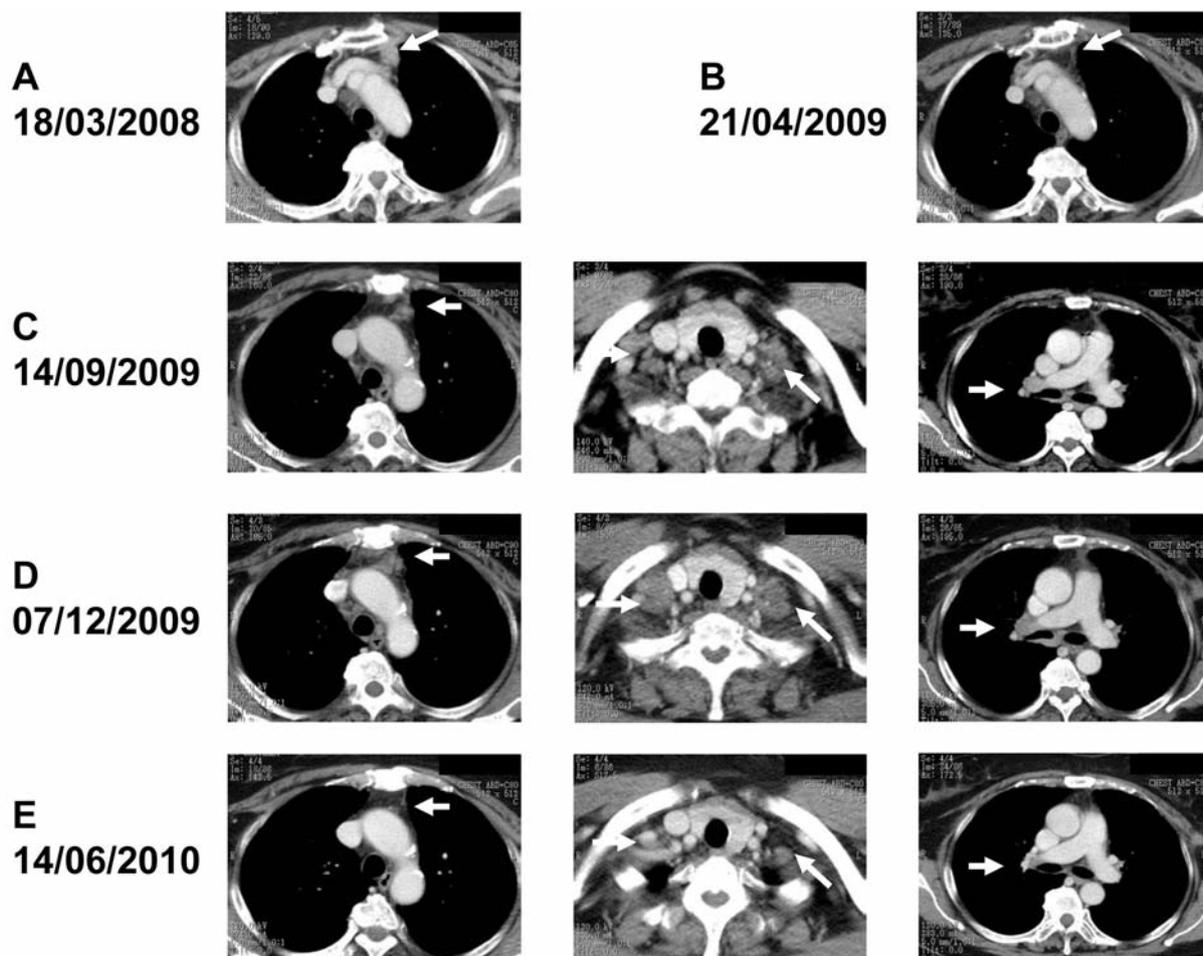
Chest computed tomography findings for metastatic tumors of breast cancer. A: The metastasis of the left parasternal lymph node (arrow). B: A complete response at eight months after the initial treatment with Herceptin and capecitabine (arrow). C: Re-growth of the left parasternal lymph node metastasis (left panel, arrow) along with bilateral infraclavicular and right hilar lymph node metastases (middle and right panels, arrows). D: Progressive disease showing multiple lymph node metastases after treatment with lapatinib and capecitabine (arrows). E: Marked shrinkage of multiple lymph node metastases induced by the second treatment with Herceptin and capecitabine following treatment with lapatinib and capecitabine (arrows).
